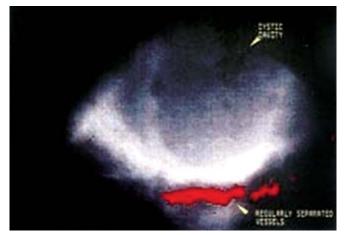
Regularly separated vessels are detected at the periphery of the dermoid cyst by three-dimensional power Doppler imaging
